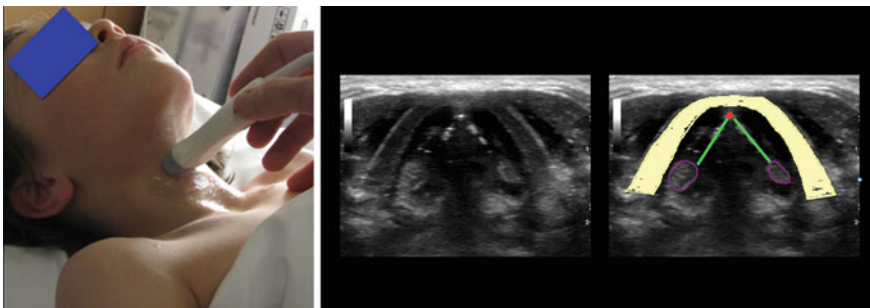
Larynx with vocal cords. *Left* The linear transducer is placed transversely over the thyroid cartilage at the level of the vocal cords. *Middle* The ultrasound image. *Right* thyroid cartilage (light yellow); the free edge of the vocal cords (green); the anterior commissure (red dot); the arytenoid cartilages (purple)
